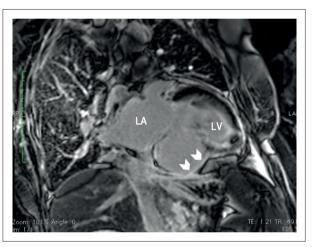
Cardiac magnetic resonance imaging, after gadolinium injection, showing the presence of late enhancement over the pericardial leaflets (arrowheads), supporting the diagnosis of pseudoaneurysm. LA, left atrium; LV, left ventricle.
